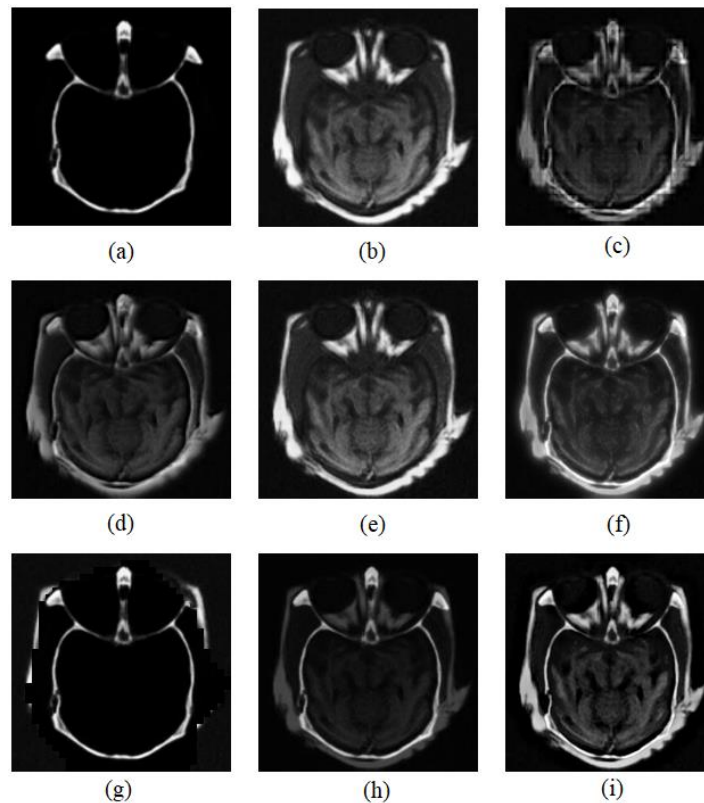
Visual quality of the fused images of: (a) CT (b) MRI (c) DWT (d) SIDWT (e) PCA (f) LAP (g) DCT_Acmax (h) DWT_Pca (i) Proposed.
